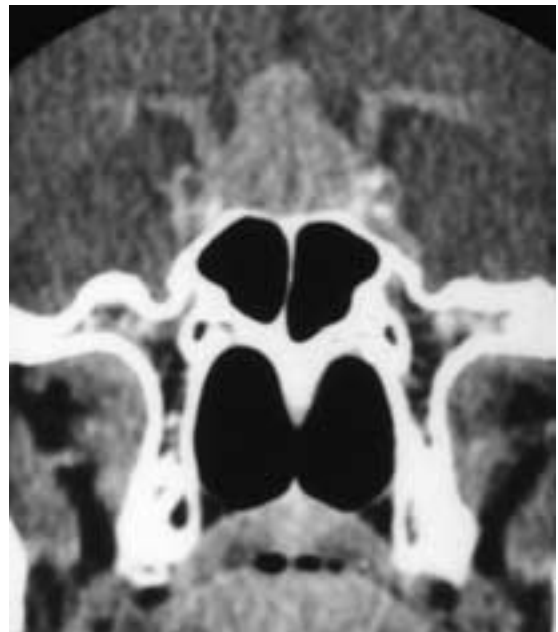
Pituitary adenoma; coronal contrast-enhanced CT image shows upward enlargement of the pituitary gland. The optic chiasm is affected.
